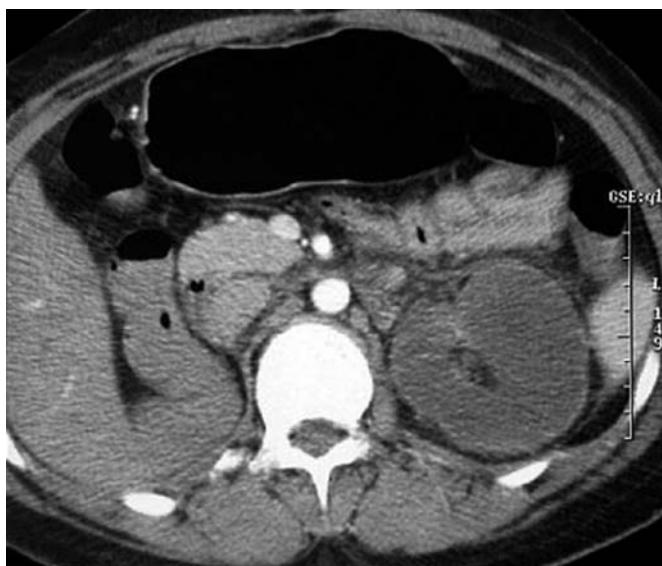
CT andomen in ARDS
